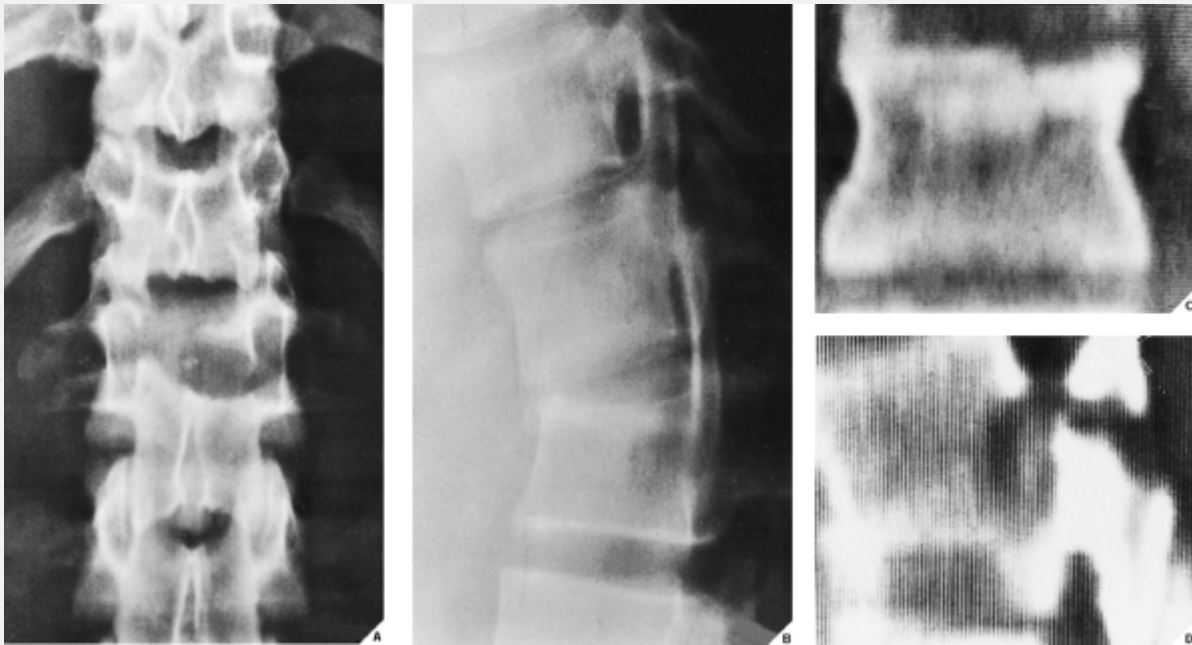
Burst fracture. A 56-year-old merchant seaman fell from a 60-foot-high ladder on a ship. Anteroposterior (A) and lateral (B) films of the lumbar spine show a burst fracture of the body of L-3. Note widening of the interpediculate distance on the anteroposterior radiograph, the hallmark of burst fracture. The severity of the injury, however, is better appreciated on a CT section (C) through the body of L-3. There is comminution of the vertebral fracture and displacement of two bony fragments into the spinal canal, with compression of the thecal sac, indicating involvement of anterior and middle columns. (D) In another patient, a 26-year-old man with a burst fracture of L-3, sagittal T1-weighted MR image (SE; TR 800/TE 20 msec) demonstrates posterior displacement of the middle column with compression of the thecal sac. (E) A sagittal T2-weighted MR image of a 58-year-old man who fell from the roof of a three-story building shows a typical appearance of a burst fracture of T-11. Note compression of the thecal sac.
